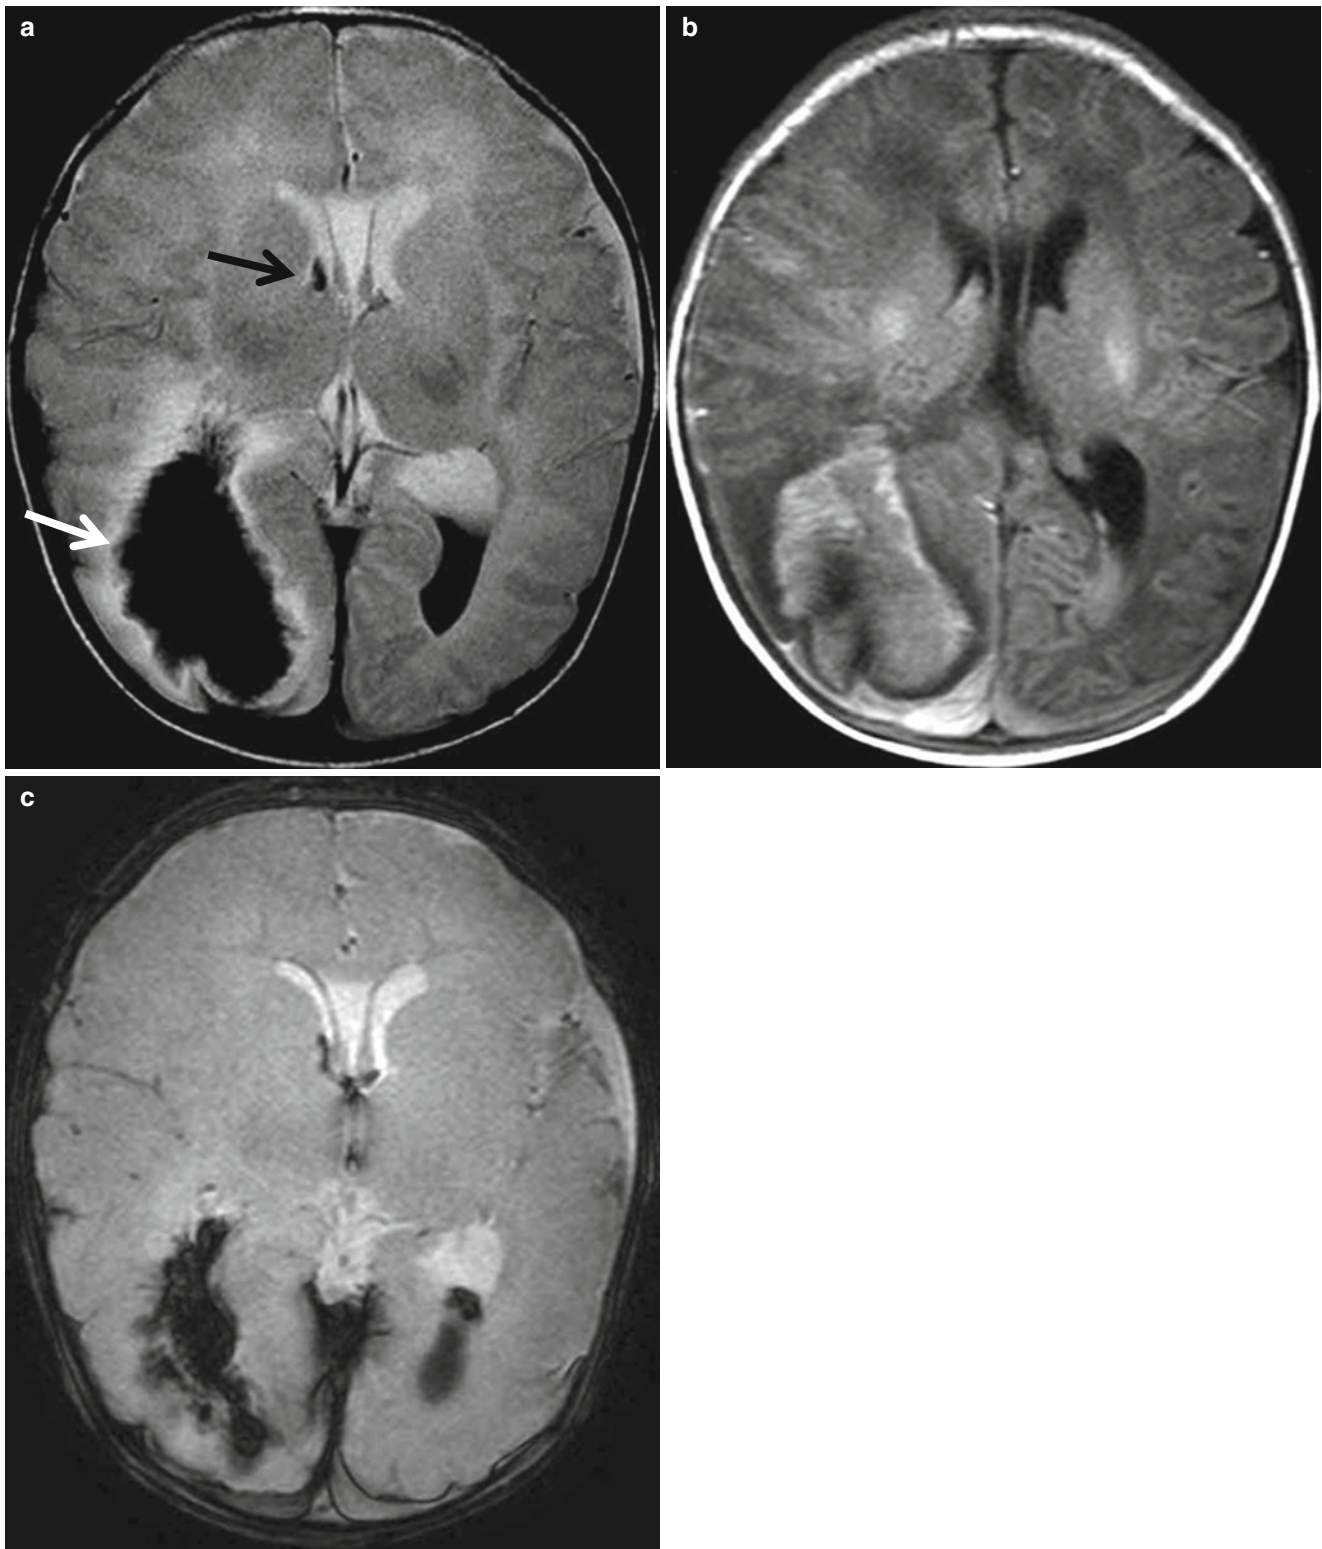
Periventricular hemorrhagic infarct (PVHI). (a) T2-weighted image shows hypointense hemorrhage extending from the ventricle into the adjacent periventricular white matter (*white arrow*). The white matter surrounding the hemorrhage is hyperintense, and multiple streaky dark signal intensity lesions are extending from the white matter
